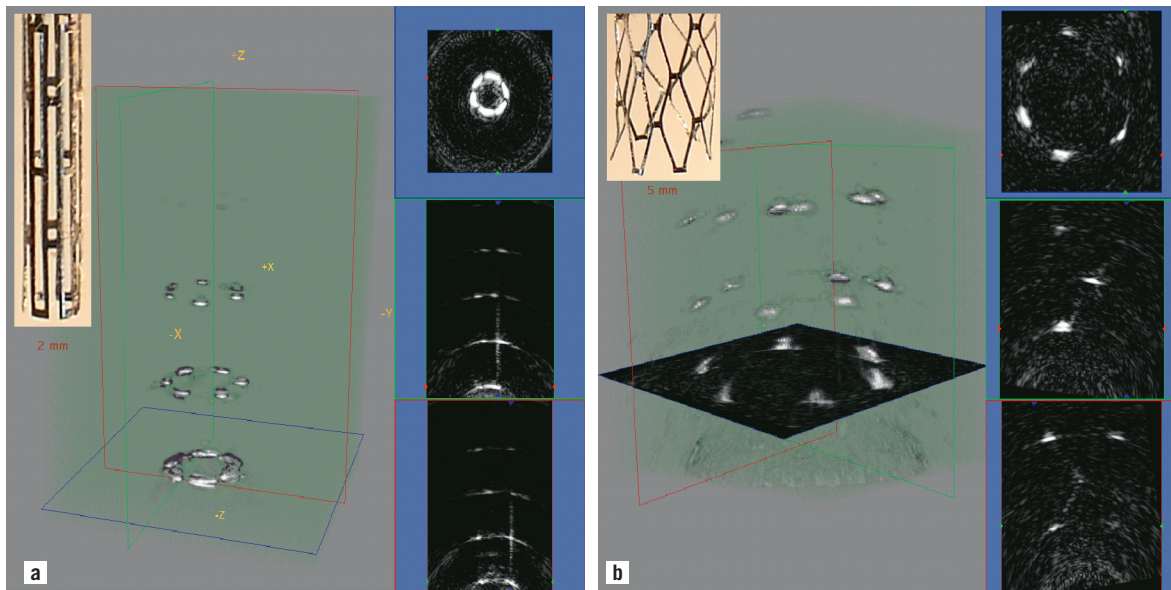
3-D rendered ultrasound images and some cross-sections acquired with the Stanford array of (a) an undeployed Palmaz-Schatz stent; and (b) a deployed Palmaz-Schatz stent.
